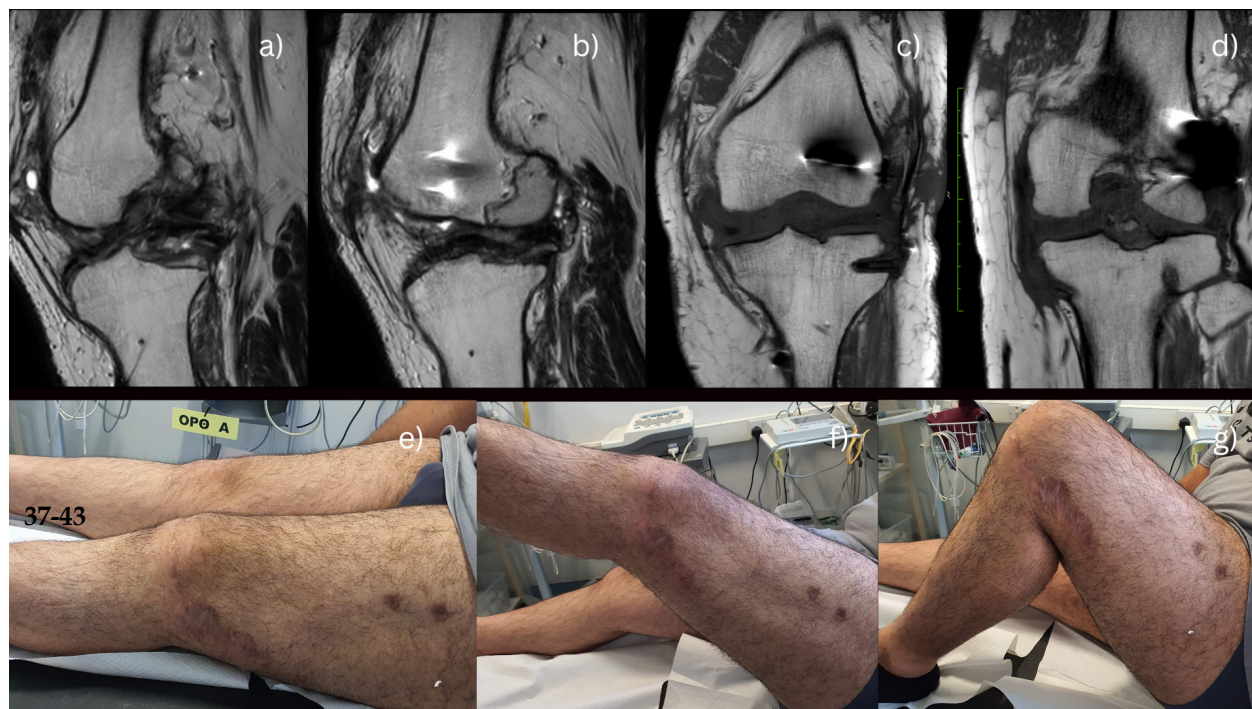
a) Post-operative MRI of the left ACL b) Post-operative MRI of the left PCL c) Post-operative MRI of the left LCL d) Post-operative MRI of the left MCL e, f) 9 months post-operatively patient is able to fully extend his left knee g) 9 months post-operatively patient is able to achieve a 90 degree flexion in his left knee
